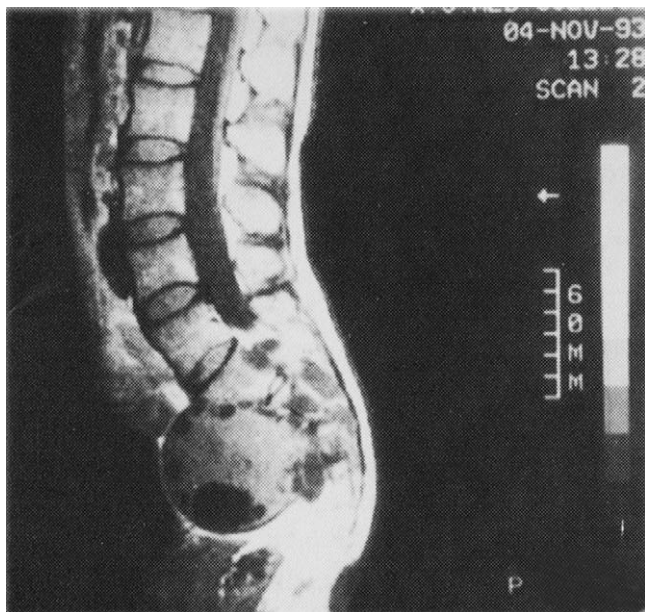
MRI showing that the T¹WI, signal of parent cyst is similar to muscle and higher than in the secondary cyst. The signal of the secondary cyst is similar to water, whether located in the parent cyst, overflowing it, or lying adjacent to it.
